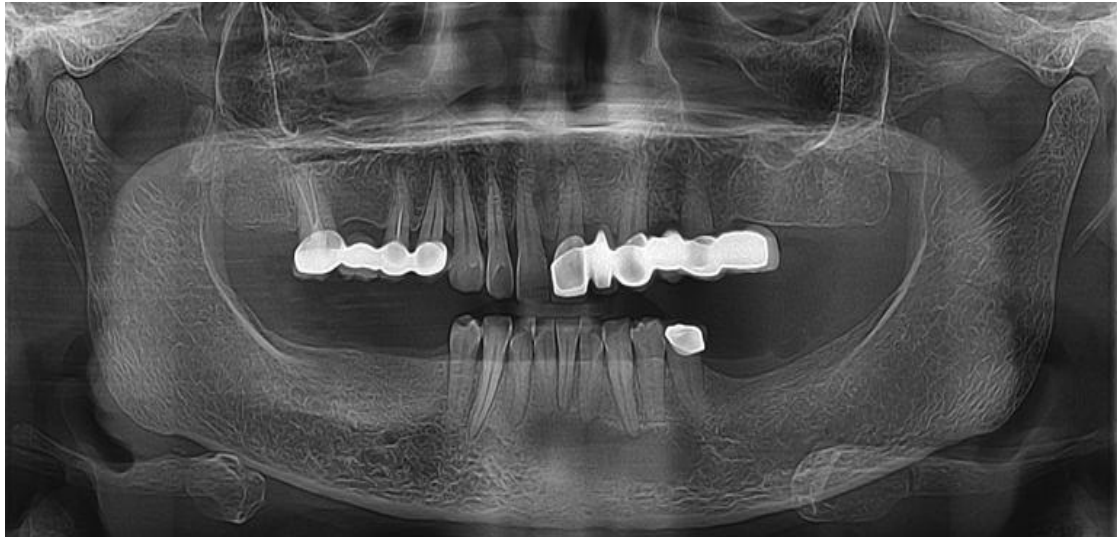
shows the Radiograph – Orthopantomography
